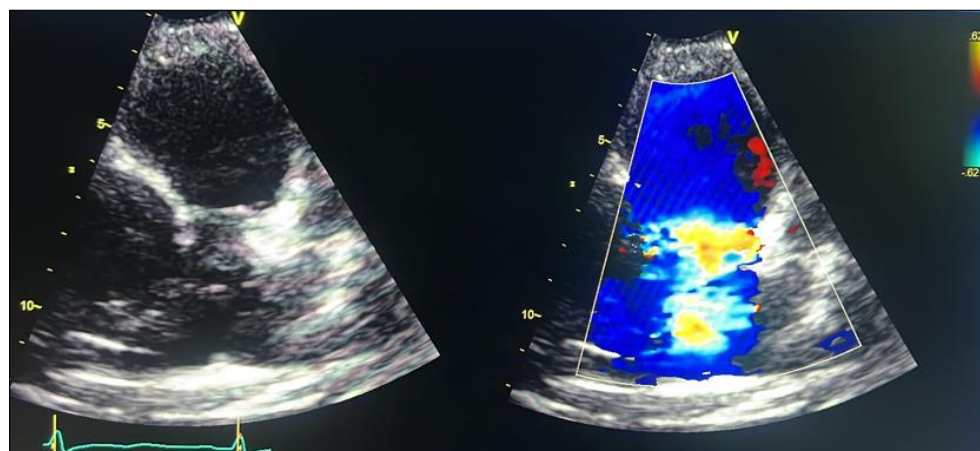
Echocardiographic image in short-axis view showing the pulmonary valve, which is mildly altered, with color Doppler aliasing indicating moderate stenosis at this level
